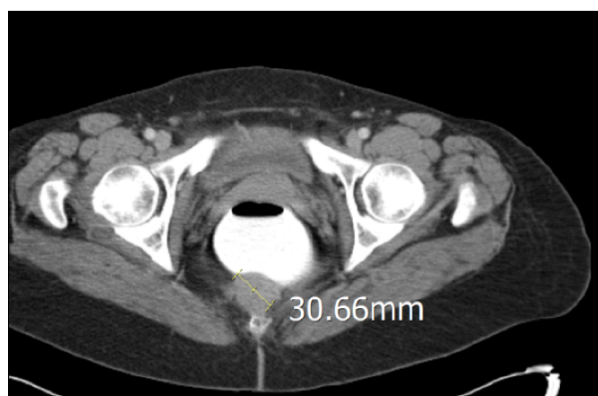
CT is useful for determining the tumor's nature (cystic or solid) and its relationship with bone structures.
